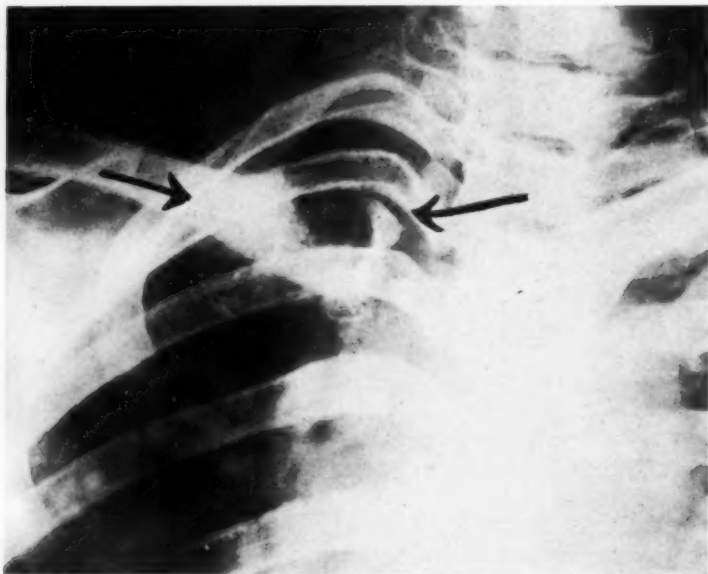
Case 5: Roentgenogram of the right clavicle exhibiting a destructive process in the medial end. There is an associated sclerosis just distal to the area of destruction. A roentgenologic diagnosis of syphilitic osteomyelitis was made before biopsy was done. The patient is responding well to antisyphilitic therapy but a definite swelling of the soft tissues overlying the medial aspect of the clavicle is still present. The symptomatic response in cases of syphilitic osteomyelitis is rapid, but the bony response is quite slow, and only after the patient has been under treatment for several months is there any appreciable change in the roentgenogram.
